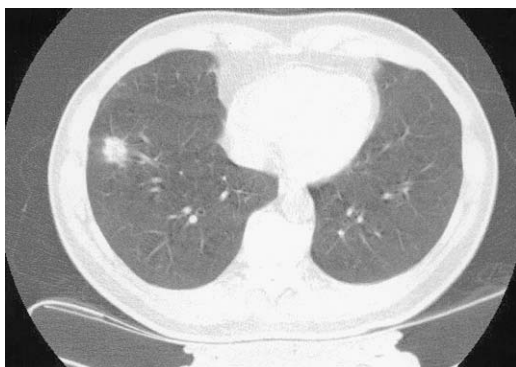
Chest CT with lung windows shows a spiculated nodule in the right lower lobe laterally. At resection this was an adenocarcinoma.
